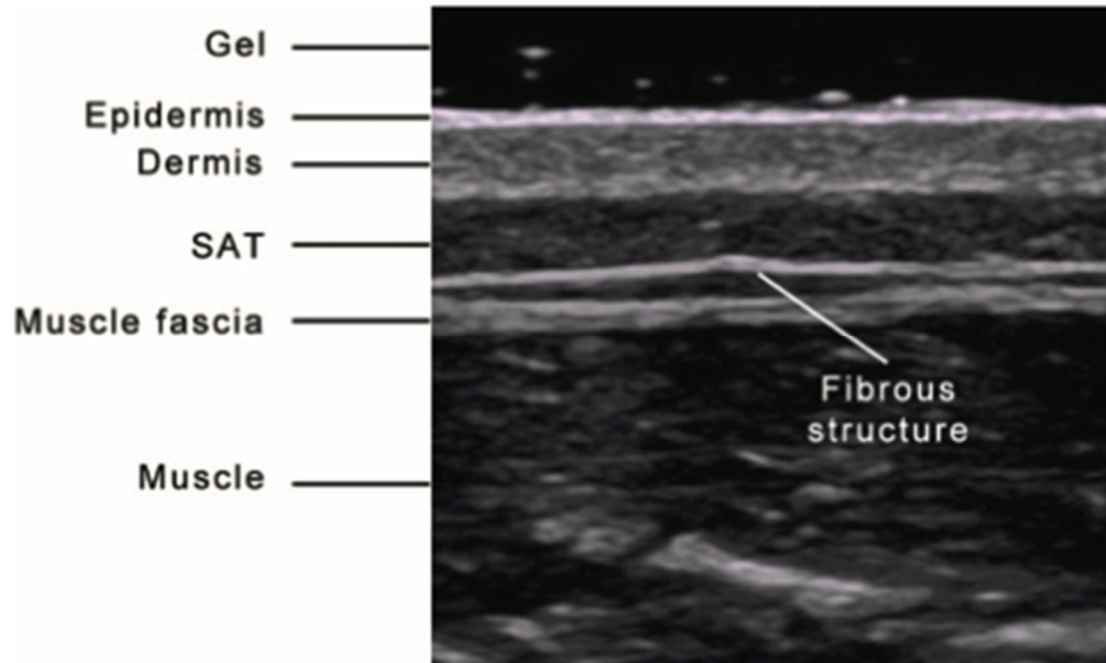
Typical picture of an ultrasound image (77)
